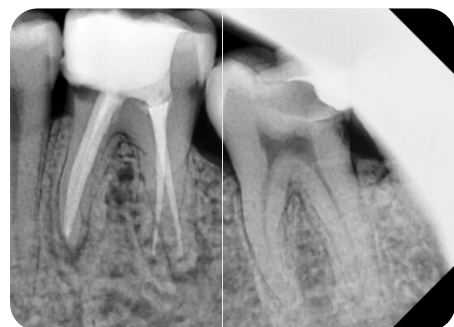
Radiograph 6months postoperatively
